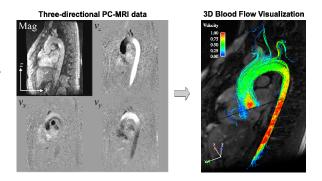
Left: Magnitude (Mag) and velocity data from 3D CINE PC-MRI in a single sagital oblique slice during systole. Each velocity image represents a Cartesian velocity component (gray-scale = velocity magnitude). Right: Blood flow visualization using 3D stream-lines in the thoracic aorta. The individual lines represent traces along the velocity vector field in a systolic time frame (color = velocity magnitude).
